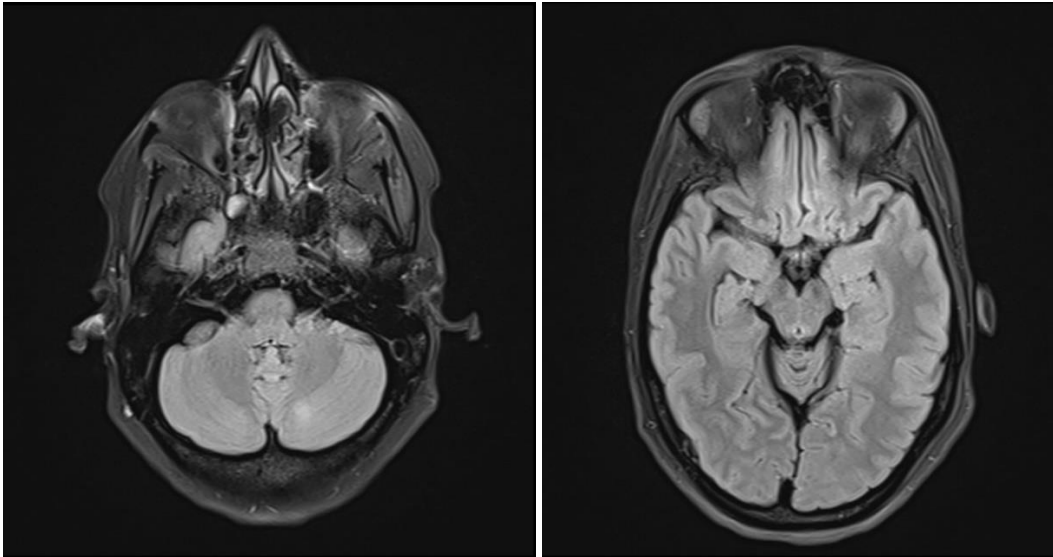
MRI showing hyper-intensity in the posterior occipital region with adjacent sulcal effacement.
